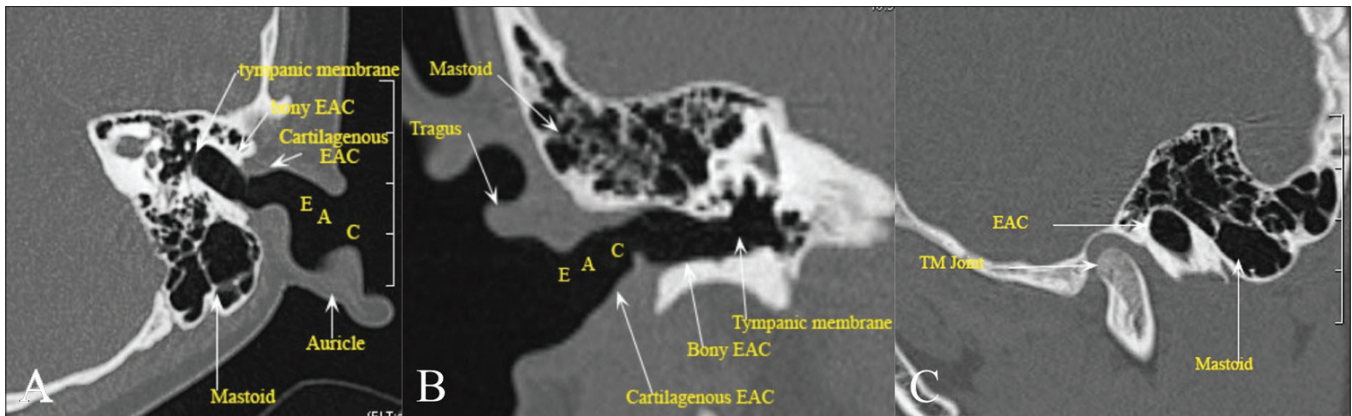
(A-C): Normal anatomy: axial (A), coronal (B) and sagittal (C) HRCT images shows parts of the external auditory canal and their relationship to surrounding structures
